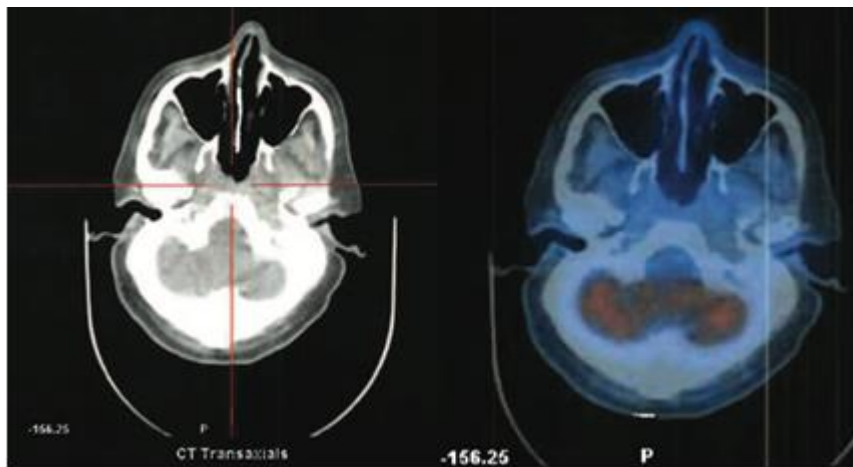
PET-CT with F-18-FDG: step reduction of the metabolic activity on the left clivus (SUV Max on late study= 3, 6)
